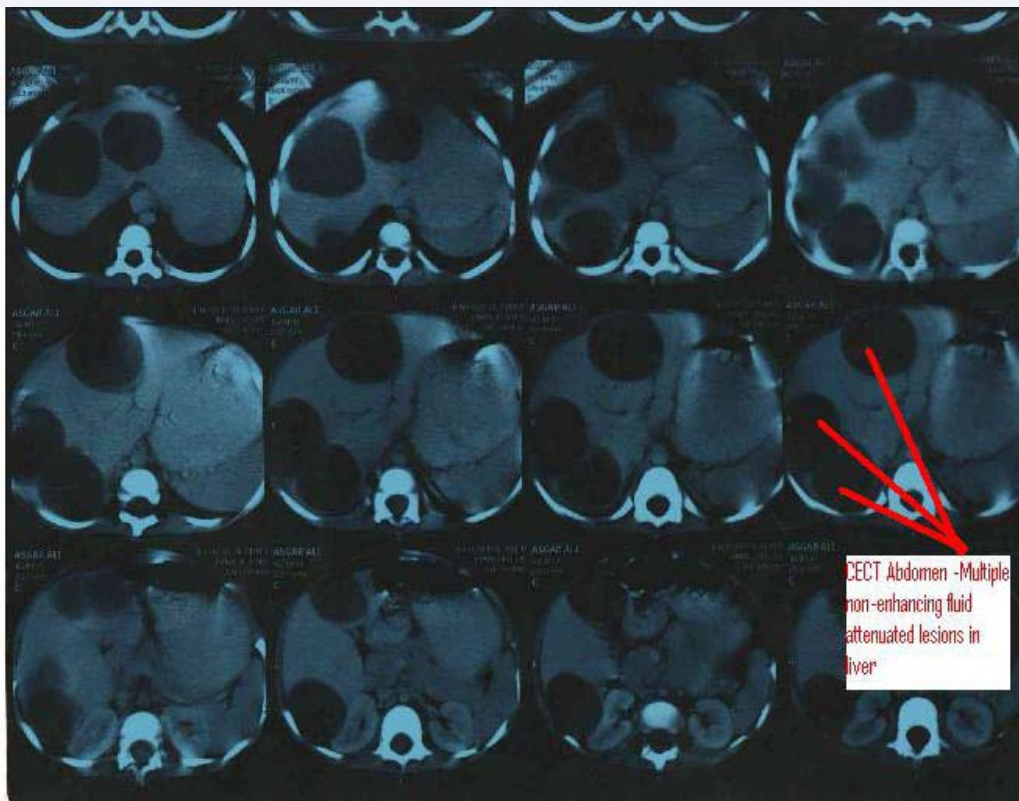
CT Abdomen: showing hepatic lesions.
